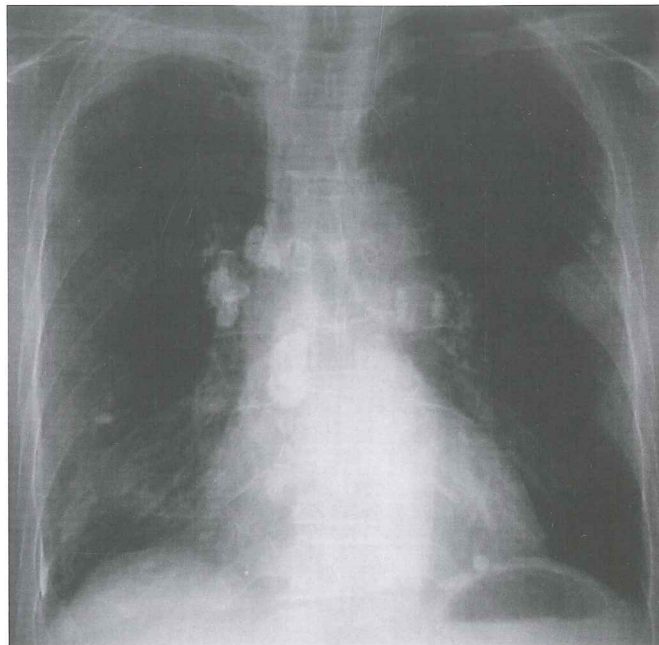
The peripheral nodule on the left side is significantly enlarged on the chest X-ray at two months follow-up (arrow).
